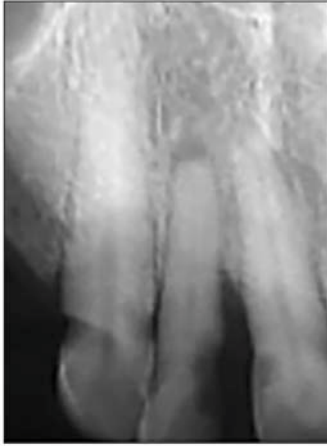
Periapical radiograph of #6 with toothbrush abrasion.
